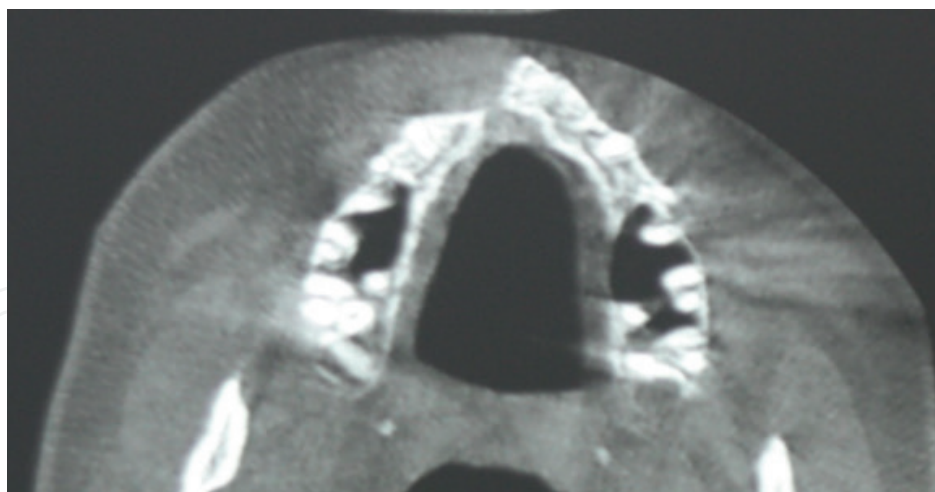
Preoperative CBCT view of a CLP case showing the graft site.
